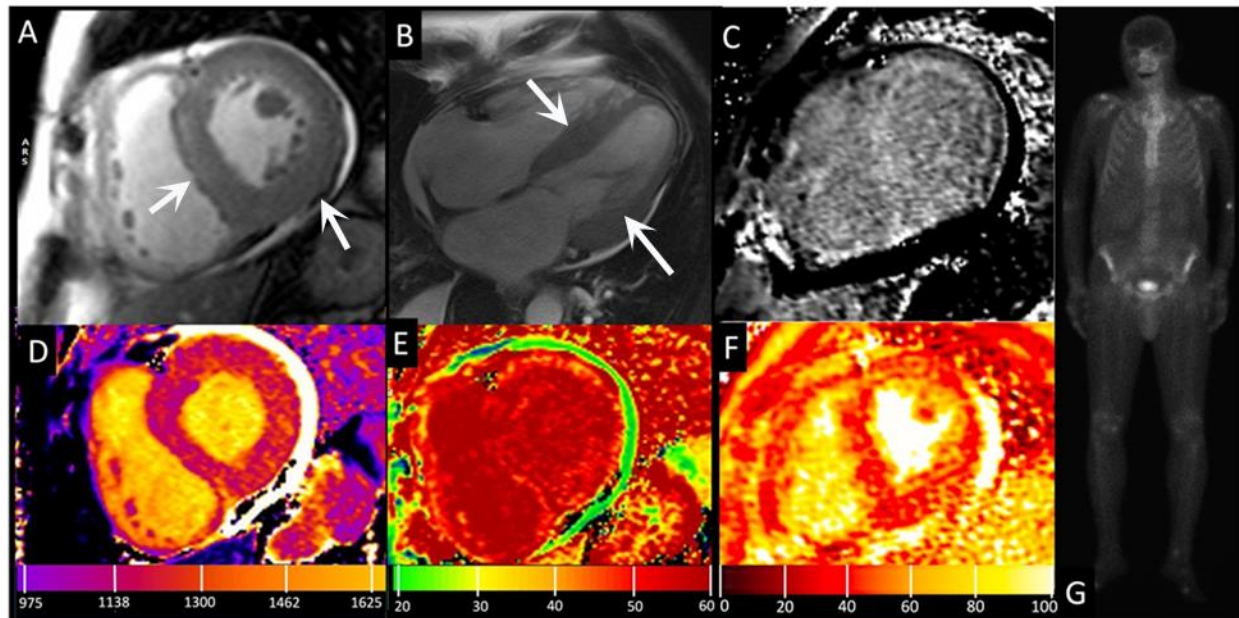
Cine CMR images acquired in short-axis (a) and four-chamber (b) views demonstrate severe left ventricular hypertrophy, marked biatrial enlargement, and a small pericardial effusion. (c) Late gadolinium enhanced image shows diffusely increased myocardial signal intensity, as typically observed in cases of diffuse fibrosis or cardiac amyloidosis. Native T1 (d) and extracellular volume (ECV) (e) maps show diffusely elevated myocardial values, raising suspicion for myocardial amyloidosis. (f) Myocardial T2 map demonstrates globally increased values, consistent with diffuse myocardial edema. Bone scintigraphy (g) did not reveal any myocardial tracer uptake, corresponding to a Perugini score of 0 and indicating a very low probability of transthyretin (ATTR) cardiac amyloidosis.
